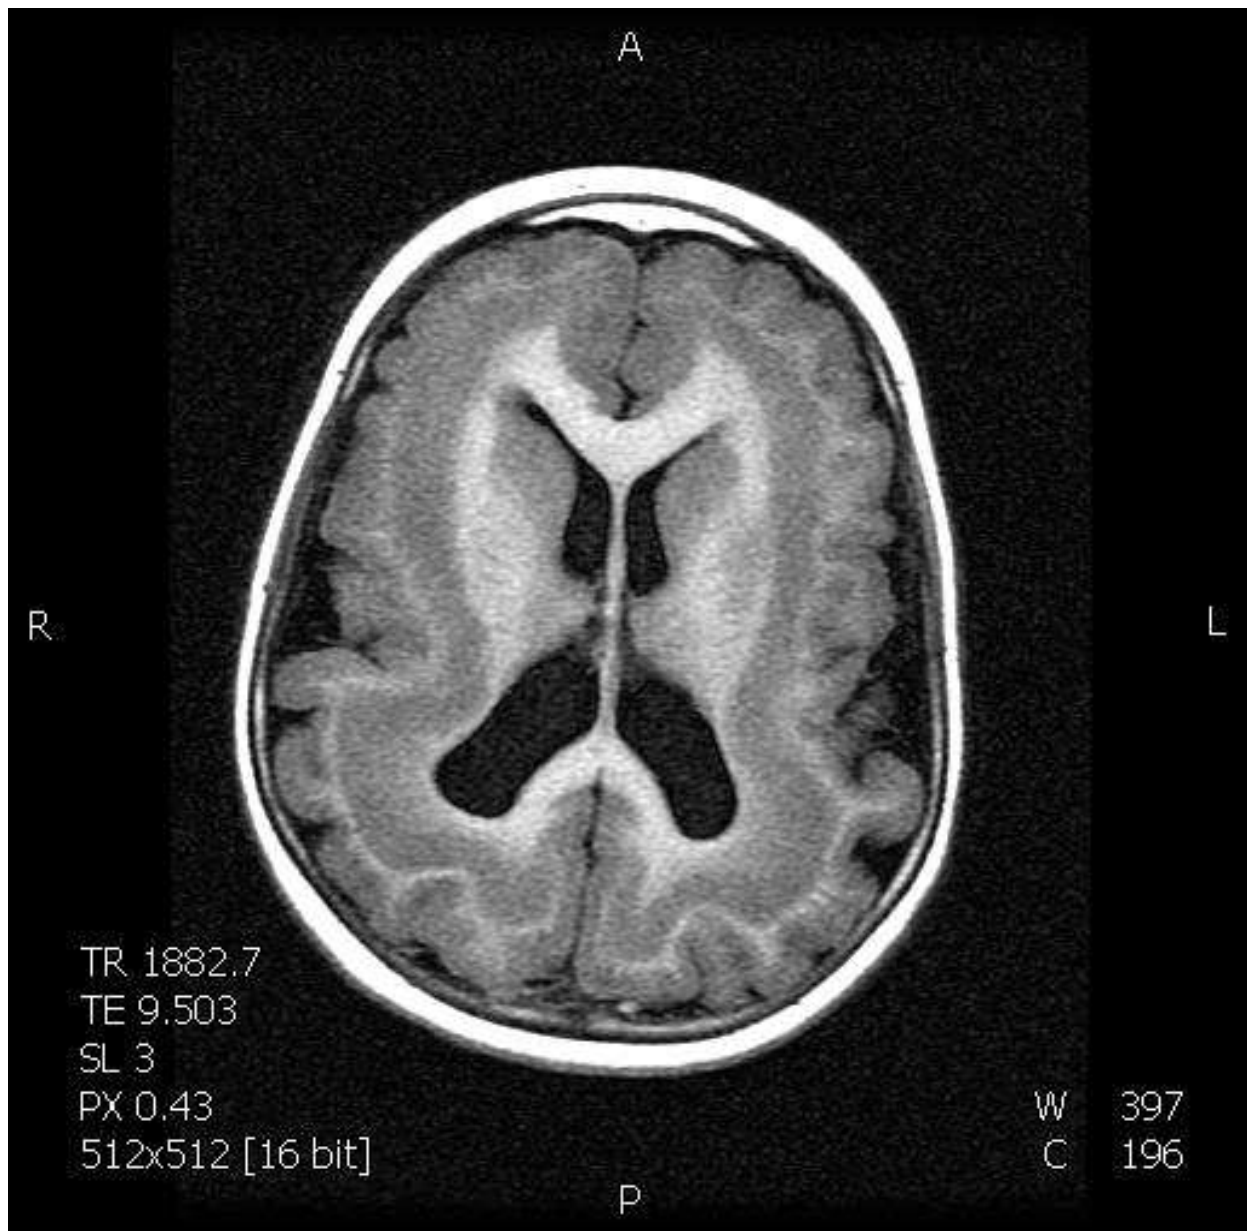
Band heterotopia: FLAIR T1 images show a thick band of heterotopic grey matter, which is separated from the cortex by a thin layer of myelinated white matter.
